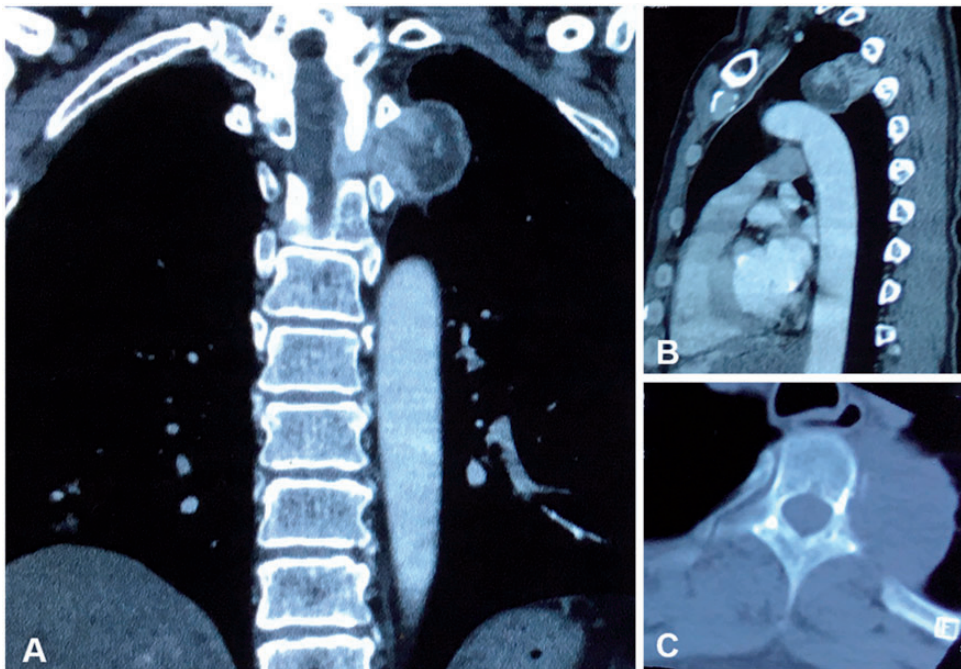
Computed tomography in the (a) coronal plane and (b) sagittal plane depicted a hemispheric soft tissue mass compromising the intervertebral foramen and vertebral body. (c) The cross-sectional computed tomography image showed that the tumor was accompanied by bone erosion.
